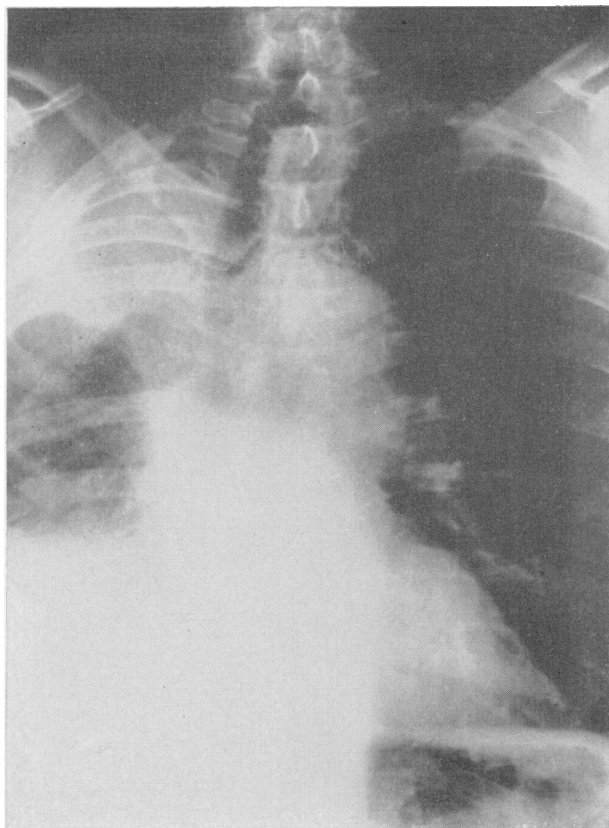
This film taken with conventional radiographic kilovoltage fails to reveal a tumor invading the left side of the trachea.
